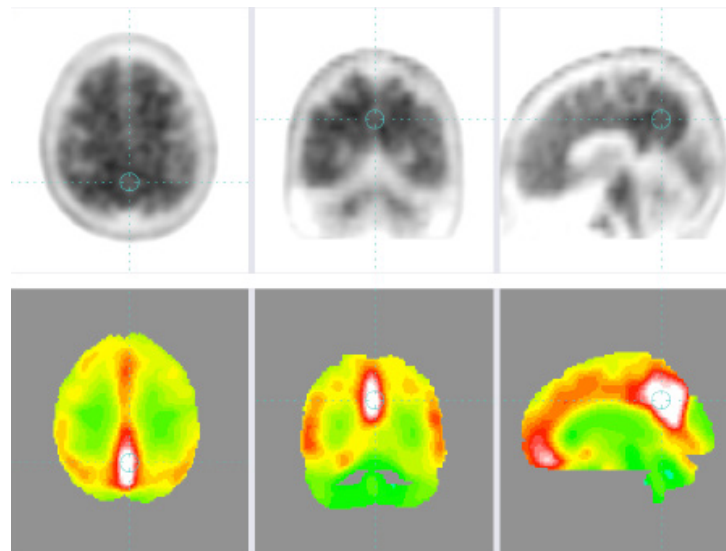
Statistics (top) and uptake (bottom) images for an FDG-PET dataset; note the high statistics (orange) visible around the crosshair (top) and the preserved activity in the central/precentral region (bottom).
